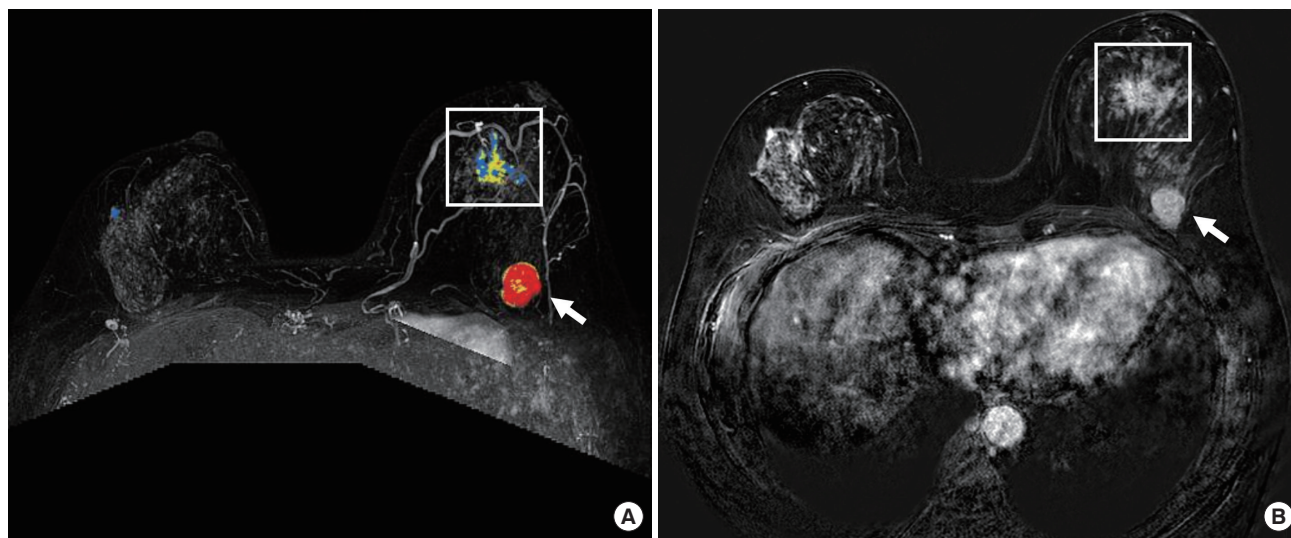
A 52-year-old woman with invasive carcinoma in the upper center quadrant and DCIS in the upper inner quadrant of the left breast assessed by MRI. A 2.4-cm, round, heterogeneous enhanced mass (arrow) at the 12 o'clock position, 10 cm from the nipple (A, contrast-enhanced dynamic scan; B, subtraction image). A 2.1-cm extent of regional NME (square) at the 10 o'clock position, 3.5 cm from the nipple, was unexpectedly noted on MRI and confirmed as DCIS. DCIS = ductal carcinoma *in situ*; MRI = magnetic resonance imaging; NME = non-mass enhancement.
